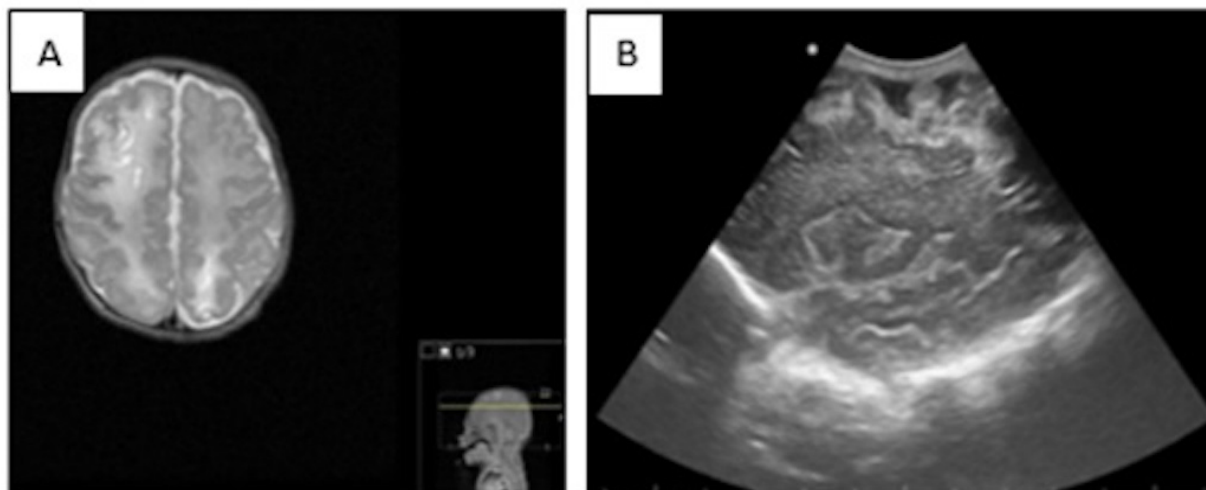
Ischemic Stroke (Watershed) at day 10 of life. (A) MRI T2 Ischemic lesions involving vascular border zones (right frontal and left parietal subcortical areas supplied by distal vessels of major arteries). (B) Cranial US: right parasagittal scan with hyperechogenicity of the right parietal convexity with cortex damage.
